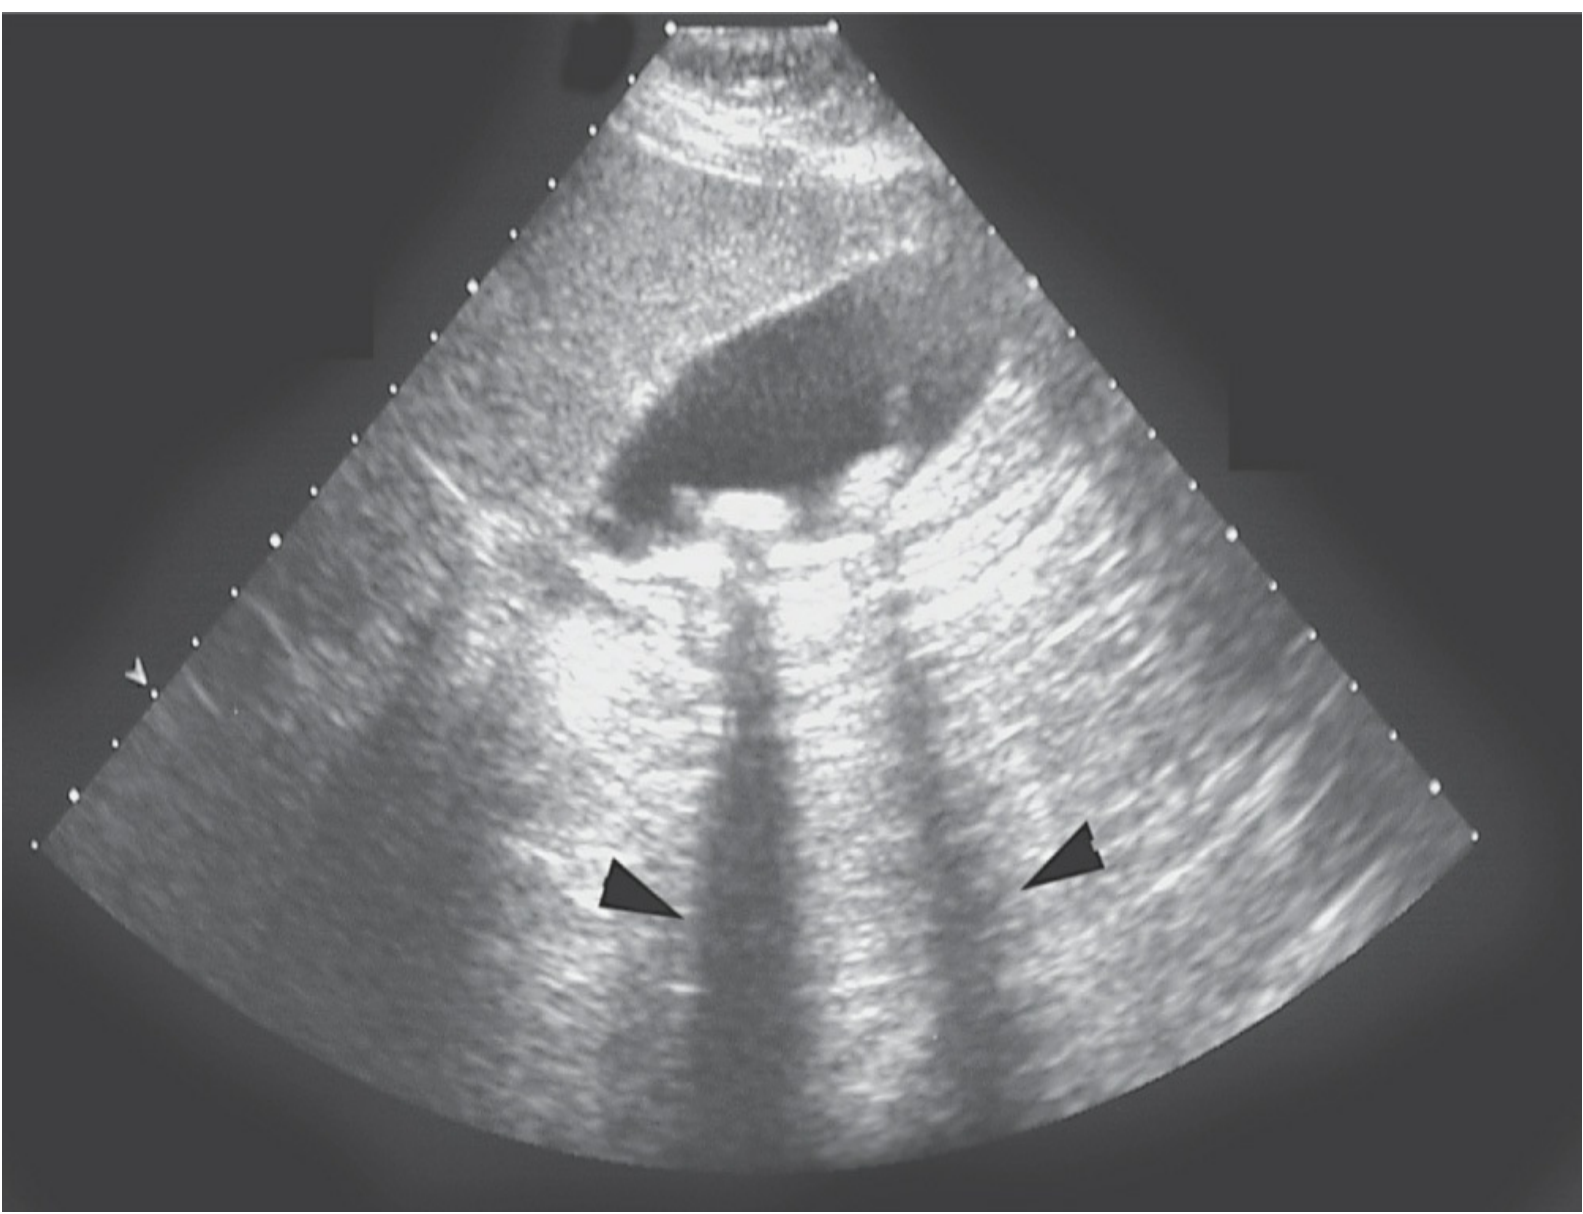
Ultrasonography showing two echogenic gallstones in the gallbladder. Note the absence of echoes posterior to the gallstone called “shadowing” (*arrowheads*). (Reproduced, with permission, from Brunicaudi FC, et al. *Schwartz’s Principles of Surgery*. 10th ed. New York: McGraw-Hill; 2015.)
